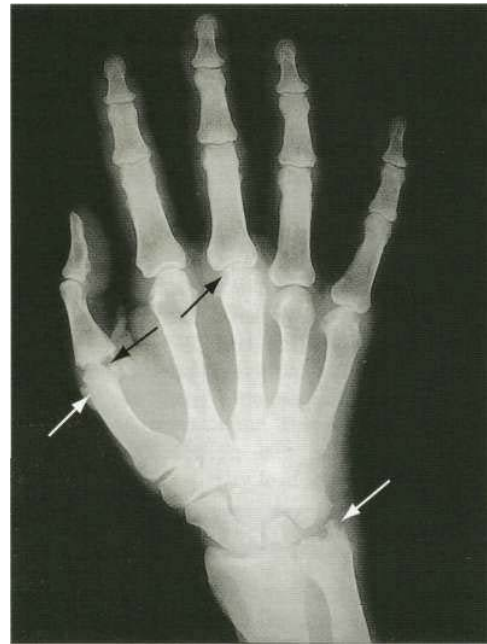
X-ray of early RA, showing typical erosions at the thumb and middle MCP joints and at the ulnar styloid.
